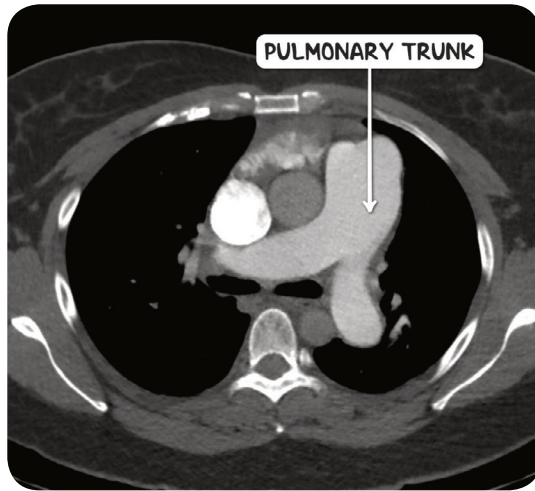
A CT scan of the chest in the axial plane demonstrating enlargement of the pulmonary trunk as a consequence of pulmonary hypertension.
